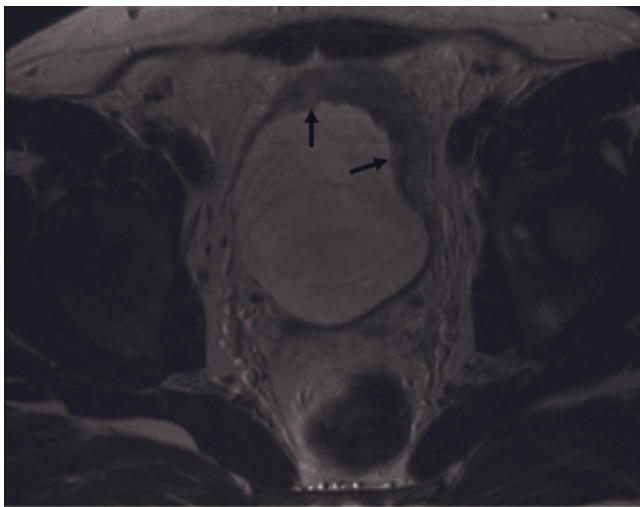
(Continued) sagittal T1-weighted postgadolinium fat-suppressed SGE (*b*) images in a third patient with adenocarcinoma. There is an irregular mass lesion arising from the anterosuperior aspect of the bladder wall, which is minimally hyperintense on T2 (*f*) and enhances mildly after gadolinium administration (*b*).
